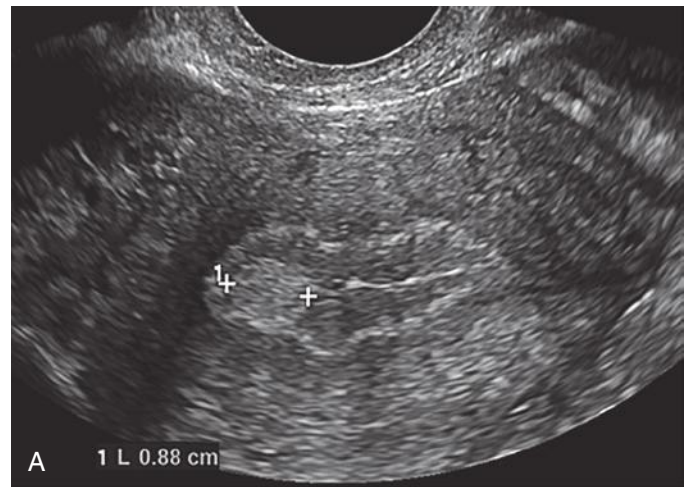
Endometrial polyp. A, Coronal gray-scale image of the uterus demonstrates a multilayered appearance of the endometrium (typical of the periovulatory phase of the menstrual cycle) and a focal echogenic lesion (calipers) representing an endometrial polyp. B, Sagittal color Doppler image shows a small feeding vessel supplying the polyp.
